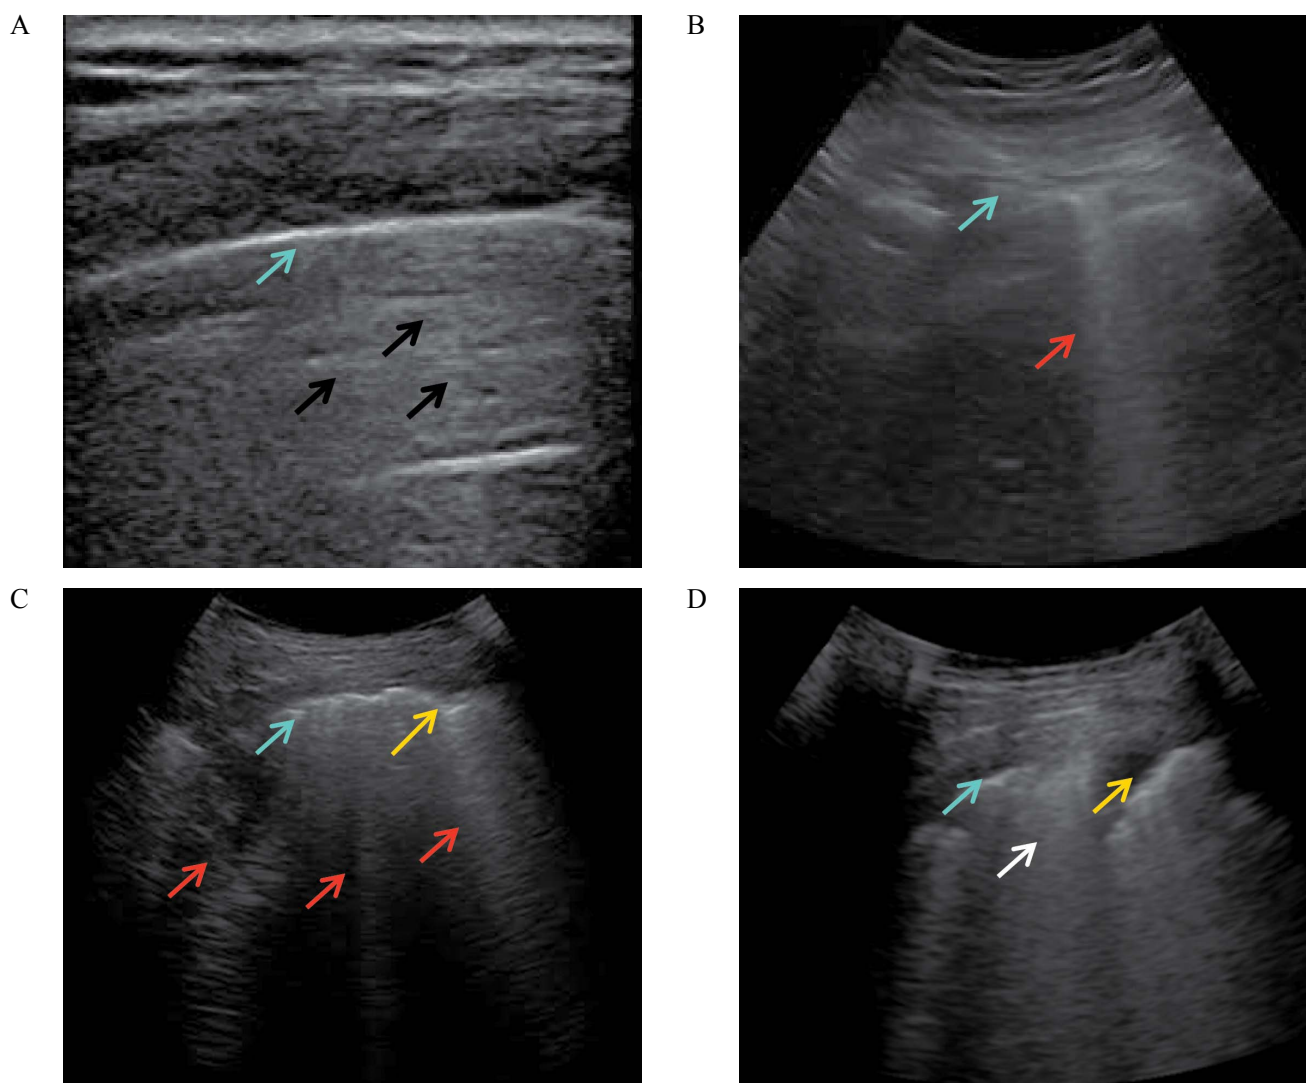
Lung ultrasound imaging and the scoring system (A–D). (A) Score 0: a regular pleural line (blue arrow) and A-lines (black arrows); (B) Score 1: an irregular pleural line (blue arrow) and an isolated B-line (red arrow); (C) Score 2: an irregular pleural line (blue arrow), multiple B-lines (red arrows), and consolidations (yellow arrow); (D) Score 3: an irregular pleural line (blue arrow), large area of white lung (white arrow) and subpleural consolidations (yellow arrow).
